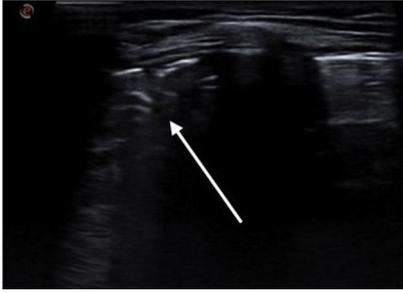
Lung ultrasound. Same consolidation pattern with bronchogram (arrow).
